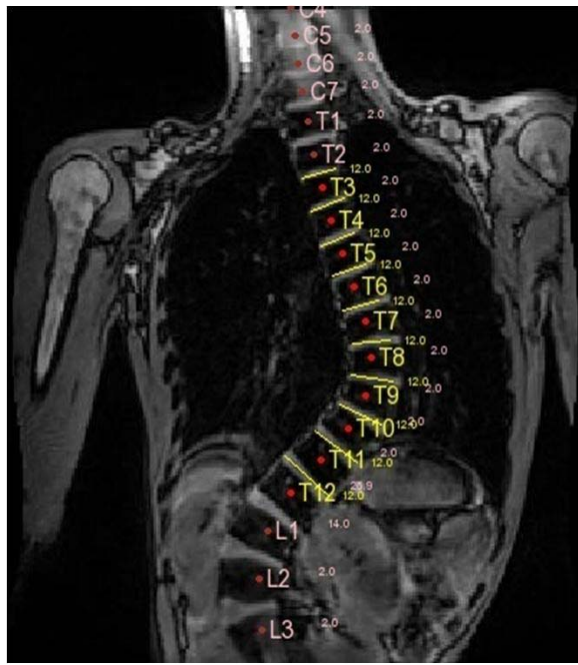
Automatic spine labeling and curved reformat (of a scoliotic patient) in a MR image.
